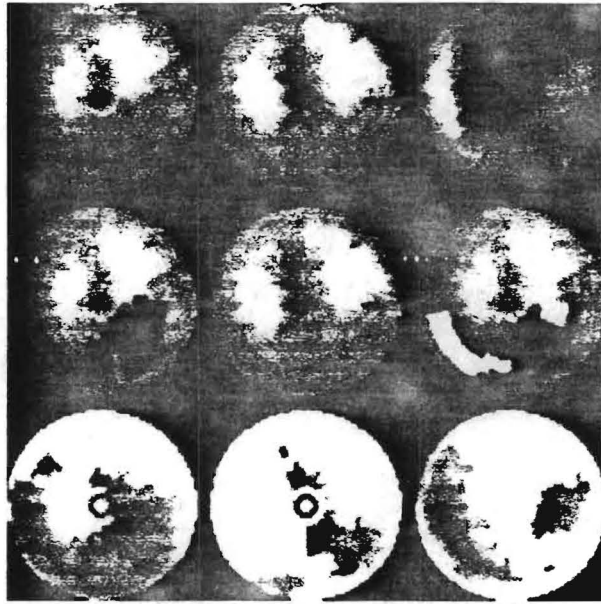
Polar representation of SPECT perfusion information.
